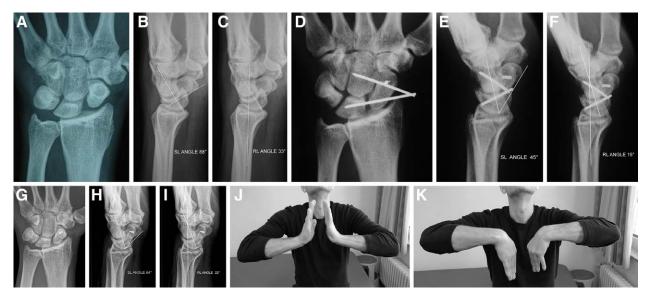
Case number 7. A–C, A 35-year-old man who had a motorcycle accident with trauma of his left nondominant wrist 6 months before. Radiographs show evident signs of static scapholunate instability. D–F, Postoperative radiographs show correct carpal alignment. G–I, Radiographs at 14-years follow-up show loss of carpal alignment but no signs of degenerative osteoarthritis. J–K, Function at 14-years follow-up. No pain, 76% grip of the healthy contralateral side.
